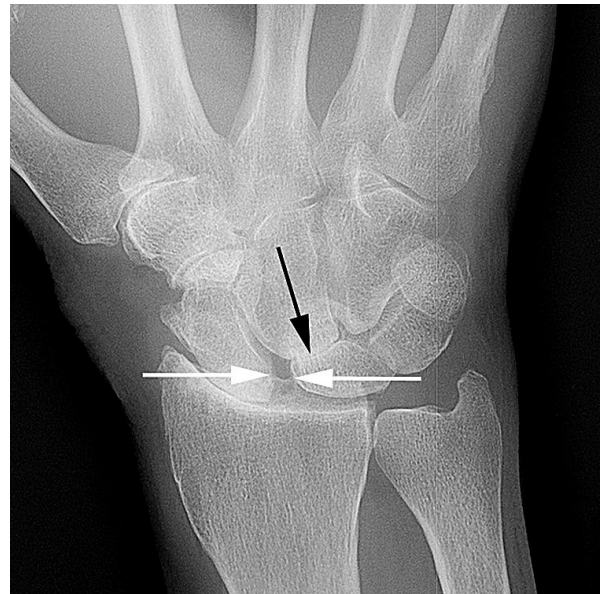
Scapholunate advanced collapse (SLAC) wrist in a 67 year old man with chronic wrist pain. AP plain film exam shows widening of the scapholunate interval (white arrows) and proximal migration of the capitate with elimination of the joint between the capitate and lunate (black arrow), along with degenerative changes between the scaphoid and radius.
